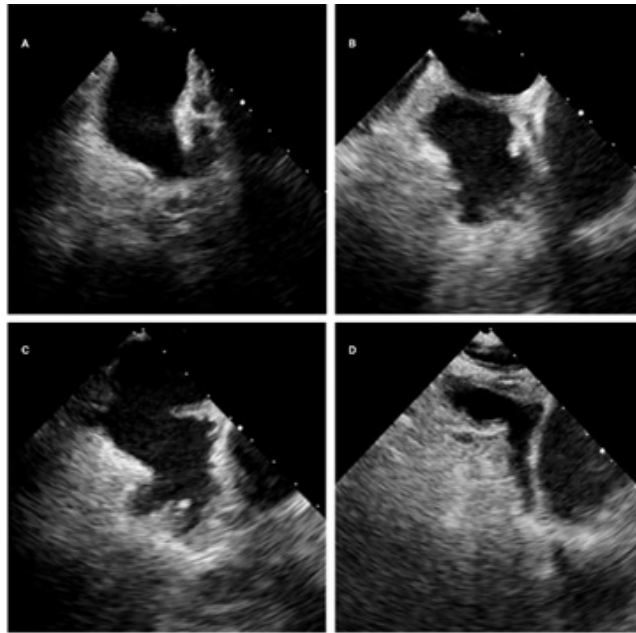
Left atrial appendage morphology by 2D transesophageal echocardiography: (A) Chicken-wing. (B) Cauliflower. (C) Cactus. (D) Windsock
